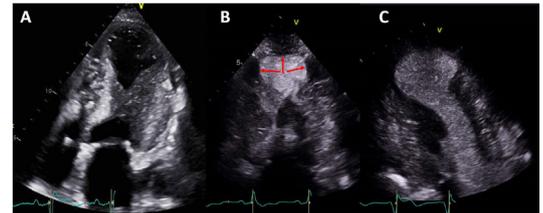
Transthoracic echocardiographic images showing systolic midventricular obstruction in a four-chamber apical view preoperatively (A) and left ventricular opacification with ultrasound contrast and a suspected layered apical thrombus producing filling defects (red arrows) in a two-chamber apical view (B). The thrombus is later confirmed with cardiac MRI and is no longer visible after 5 months of anticoagulation (C).
